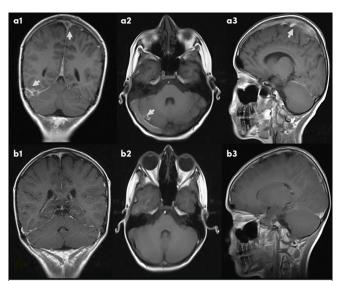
a, b. A 12-years-old male with ALL who presented with headache and drowsiness after L-asparaginase treatment (Case 13) (a) A1- coronal, A2-axial, A3- sagittal T1-weighted Cranial MR and MR venography with filling defects compatible with thrombosis of the superior sagittal sinus, right transverse sinus and sigmoid sinus in acute phase and sinus enlargement (arrow) (b) B1-coronal, B2-axial, B3-sagittal at the 1st month control MR venography showed thinning of the thrombus and recanalization in superior sagittal sinus, right transverse sinus, right sigmoidal sinus
